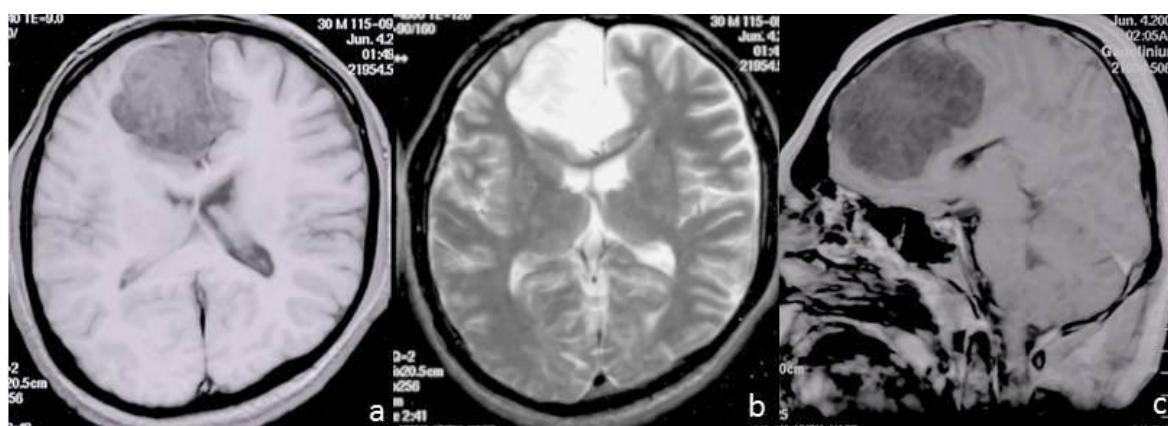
MRI brain of patient 1, (a) T-1 weighted image (axial section) showing a hypointense mass lesion in the right frontal region with subfalcine contralateral extension, (b) T-2 weighted image (axial section) producing homogenous hyperintense signals, (c) gadolinium-enhanced T-1 weighted image (sagittal section) showing no uptake of contrast material. The lesion is seen to be producing a mass effect without any surrounding edema. These findings are suggestive of an epidermoid cyst.
